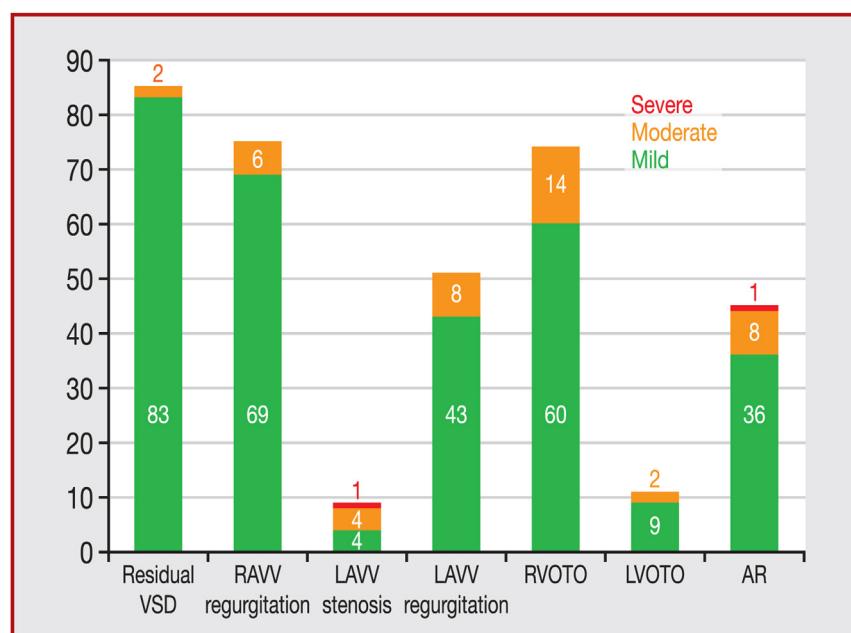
Classification of residual lesions seen on exit transthoracic echocardiography, and their severity. AR: aortic regurgitation; LAVV: left atrioventricular valve; LVOT: left ventricular outflow tract; LVOTO: left ventricular outflow tract obstruction; RAVV: right atrioventricular valve; RVOT: right ventricular outflow tract; RVOTO: right ventricular outflow tract obstruction; VSD: ventricular septal defect.
